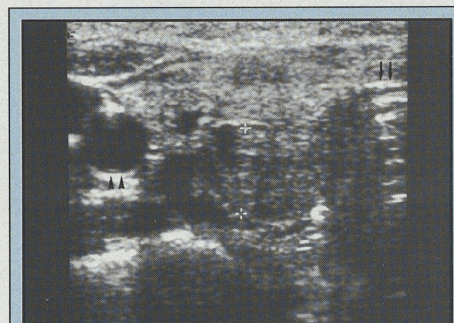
Transverse sonogram of the thyroid showing an ill defined, solid, heterogeneous thyroid nodule (calipers) in the right lobe of the thyroid. Arrows identify the trachea and arrowheads identify the common carotid artery.
